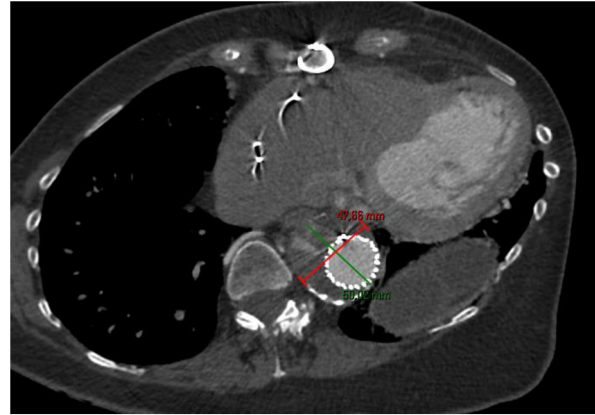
Patient B. Computed tomography angiography 2 years after placement of the custom-made fenestrated-branched endograft. There is a small type II endoleak in the sac, the size of which was reduced to a maximal oblique diameter of 48 mm.
